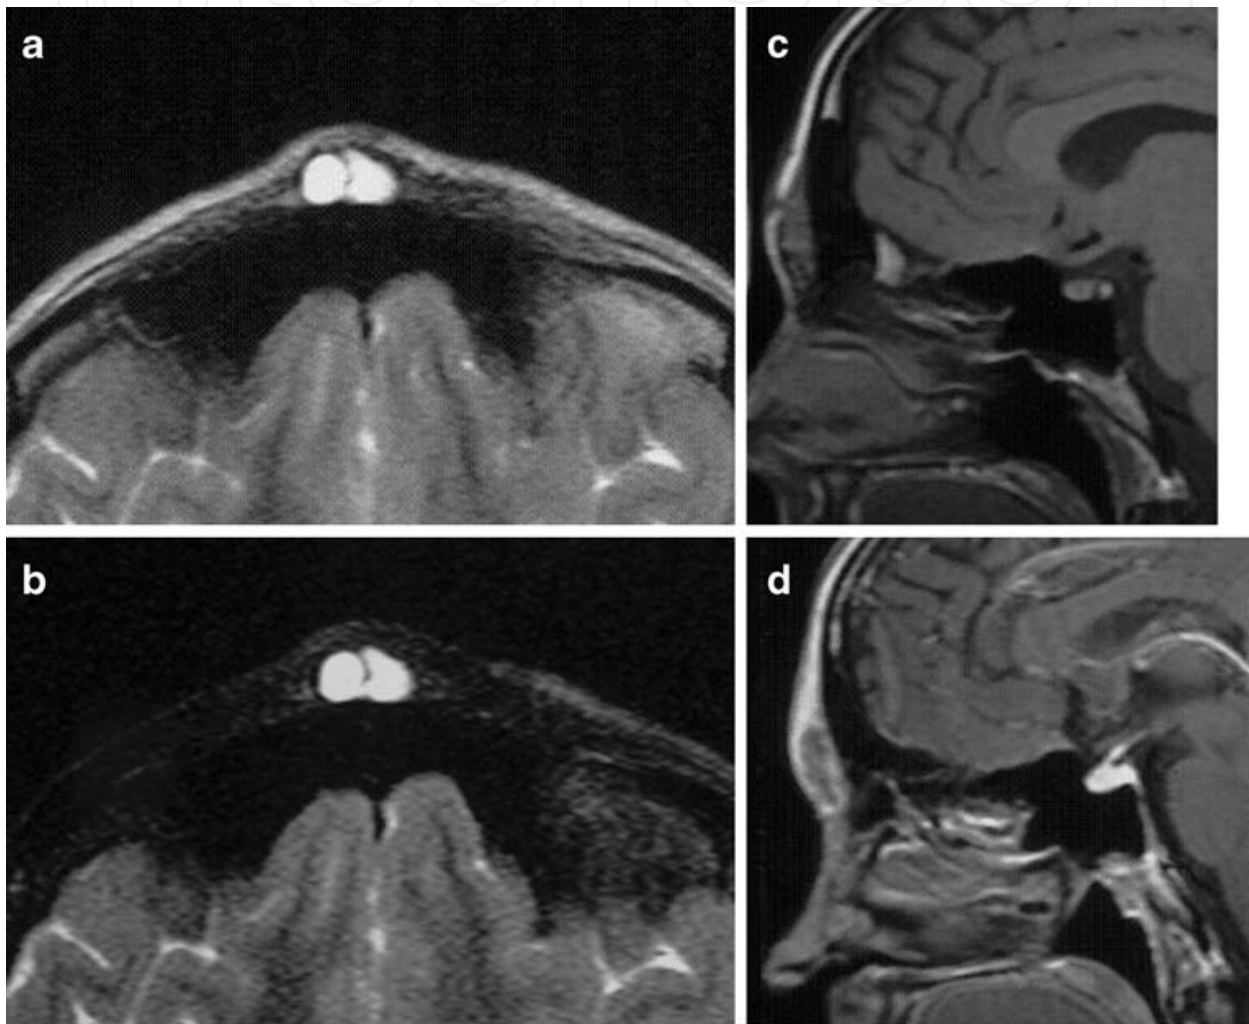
a-d Brain MRI showing an oval-shaped subcutaneous cystic lesion in the midline, in front of the frontal sinuses. The lesion shows homogeneously high signal intensity in axial T2 (a) and STIR images (b), low signal intensity in sagittal T1-weighted image (c), and peripheral enhancement in sagittal T1-weighted image after gadolinium injection (d)
